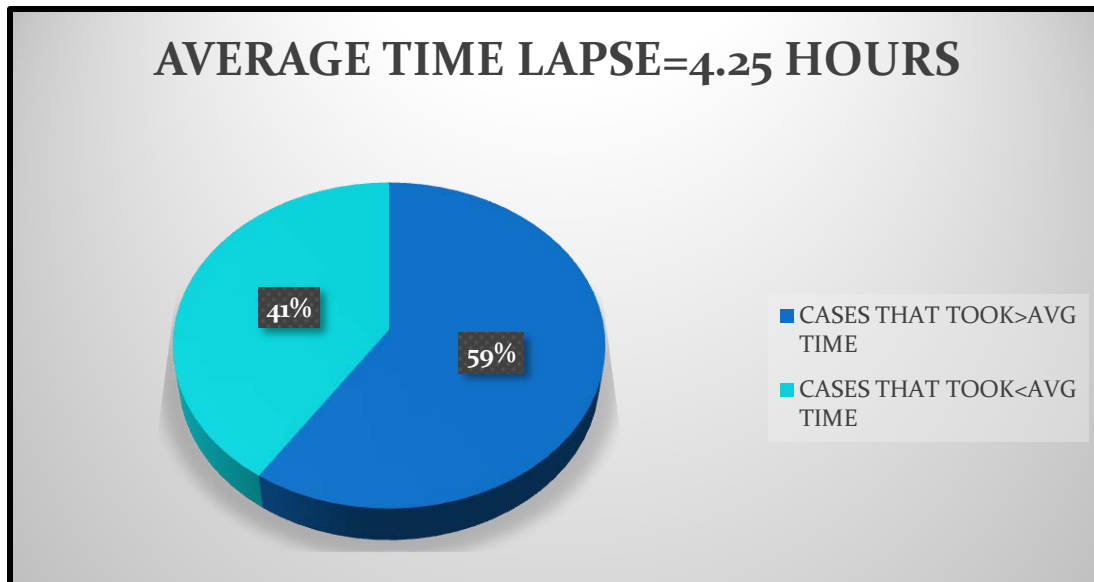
TIME LAPSE BETWEEN ORDER TIME AND TIME AT WHICH X-RAY WAS TAKEN
